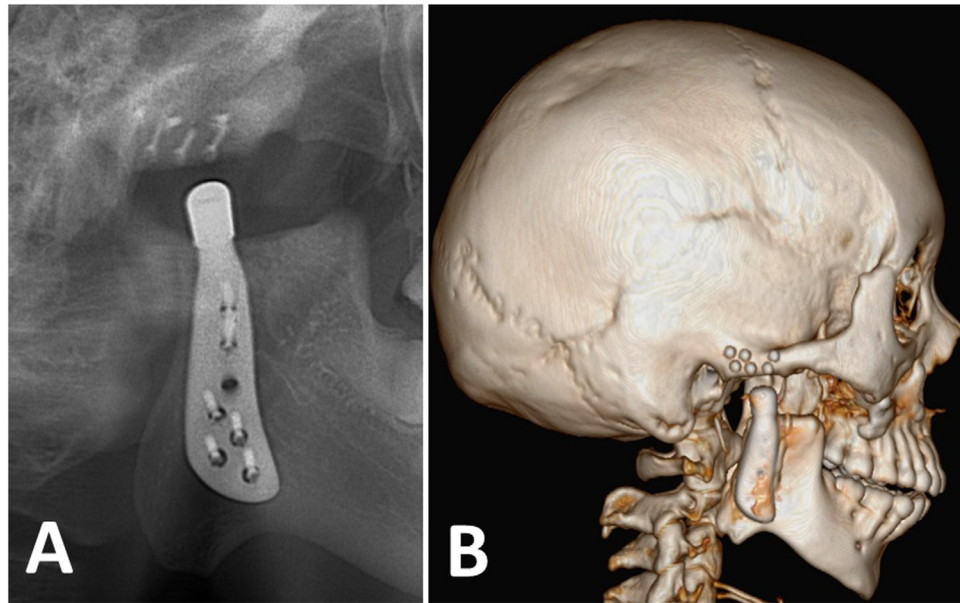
Postoperative radiographic examination. (A) Orthopantomogram. (B) Three-dimensional computed tomography image.
